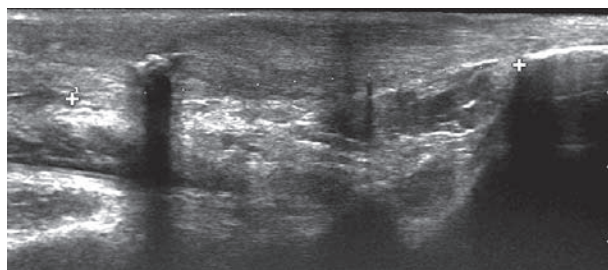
Panoramic longitudinal ultrasound scan of an operated Achille's tendon with particular on calcaneal insertion. Shadow cones of stitches can be noted
